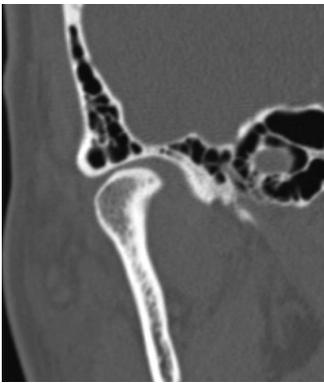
Extensive pneumatization. Coronal reformatted computed tomography image through the right temporomandibular joint demonstrates almost complete pneumatization of the glenoid fossa except the central part.
